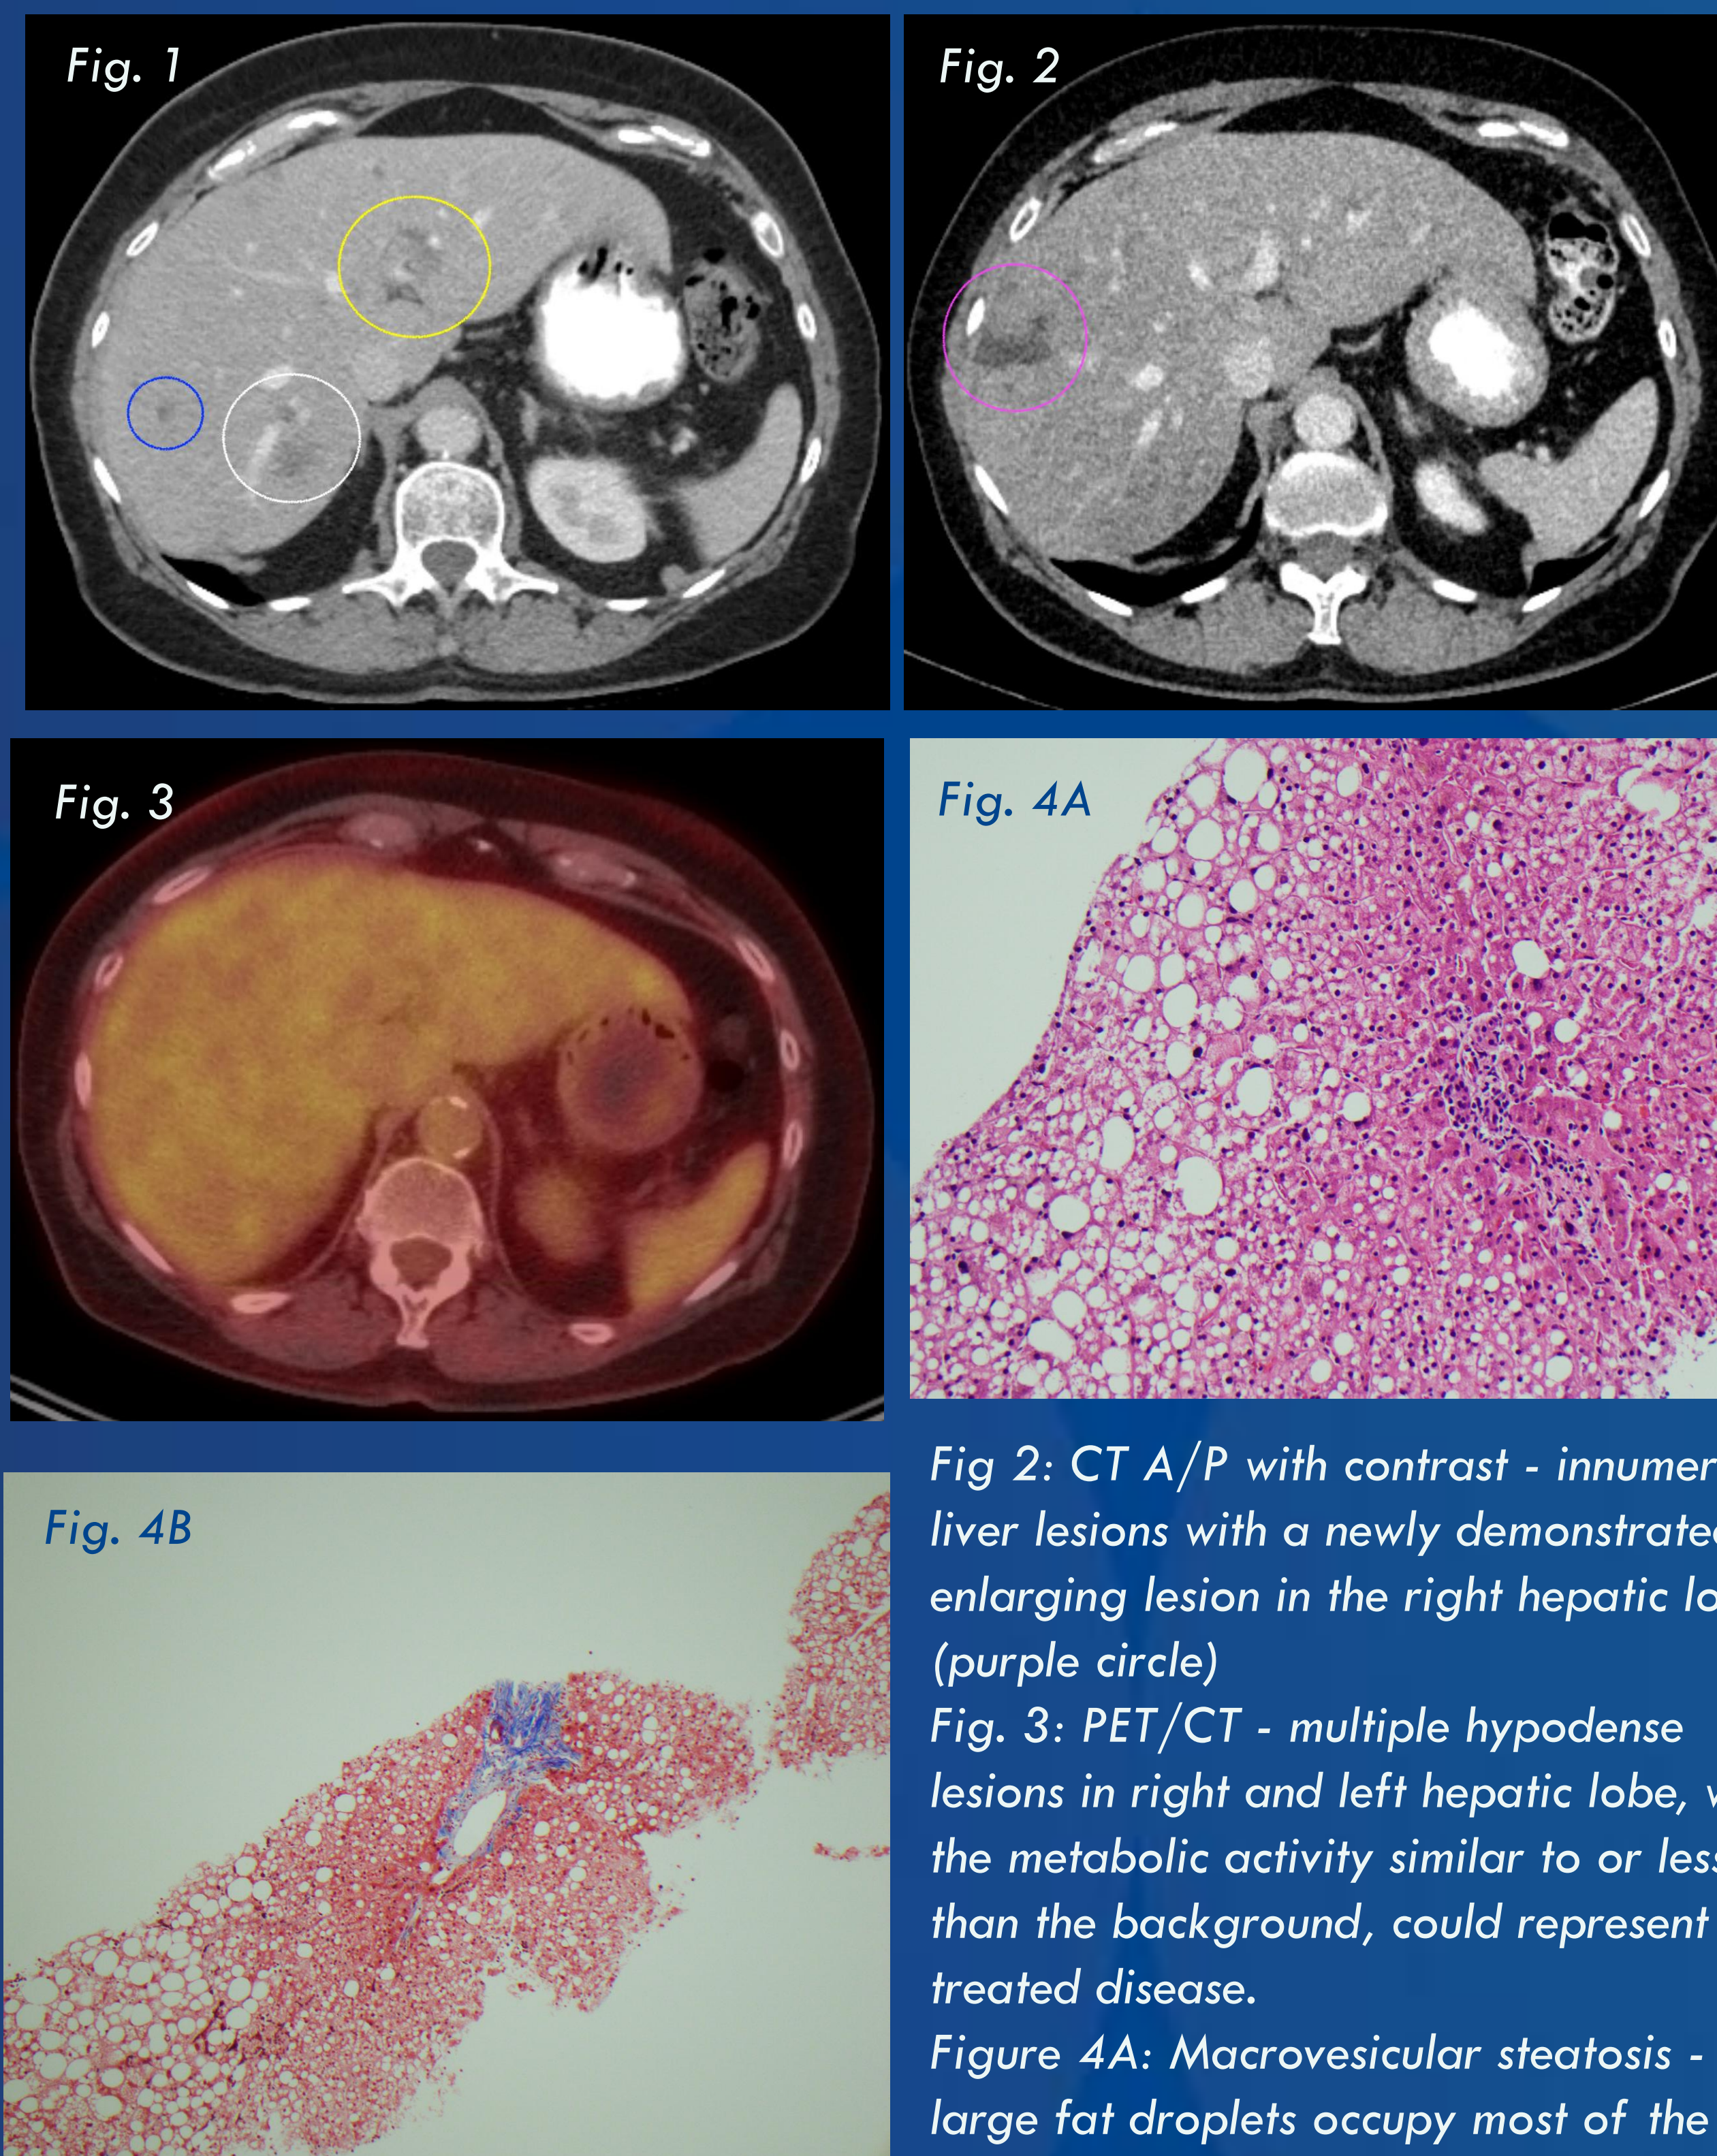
CT A/P with contrast - There are multiple hypoattenuating lesions throughout the liver consistent with metastases, for example, a 1.8 x 2.0 cm lesion in segment VII (white circle). A 0.8cm lesion (blue circle)
